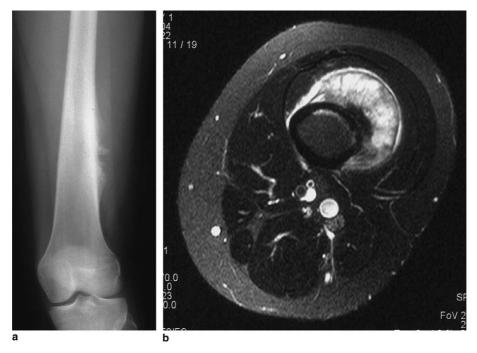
Typical radiological appearances of a periosteal osteosarcoma of the femur demonstrating: (a) the raised periosteum with calcification and (b) the MRI appearance of a subperiosteal tumour encircling the femur.
